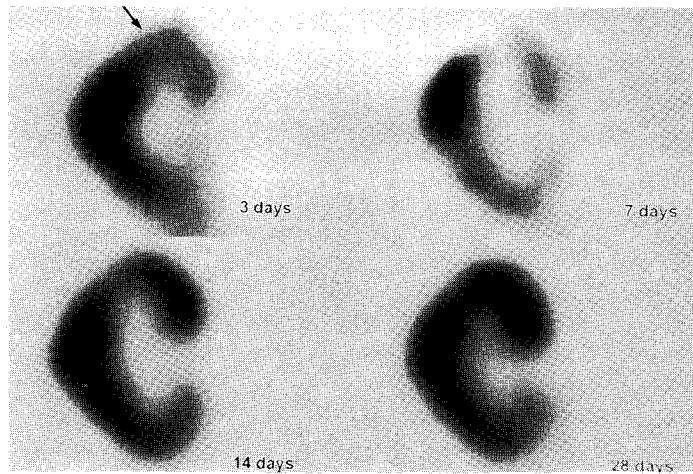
Coronal tomographs of sequential Tc-99m MAG3 renal SPECT studies in a 57 years old man with acute rejection of the allograft kidney. There is a focal area of decreased radioactivity (arrow) in the upper pole on the initial scan (3 days after surgery), which continuously improves on follow-up scans.
